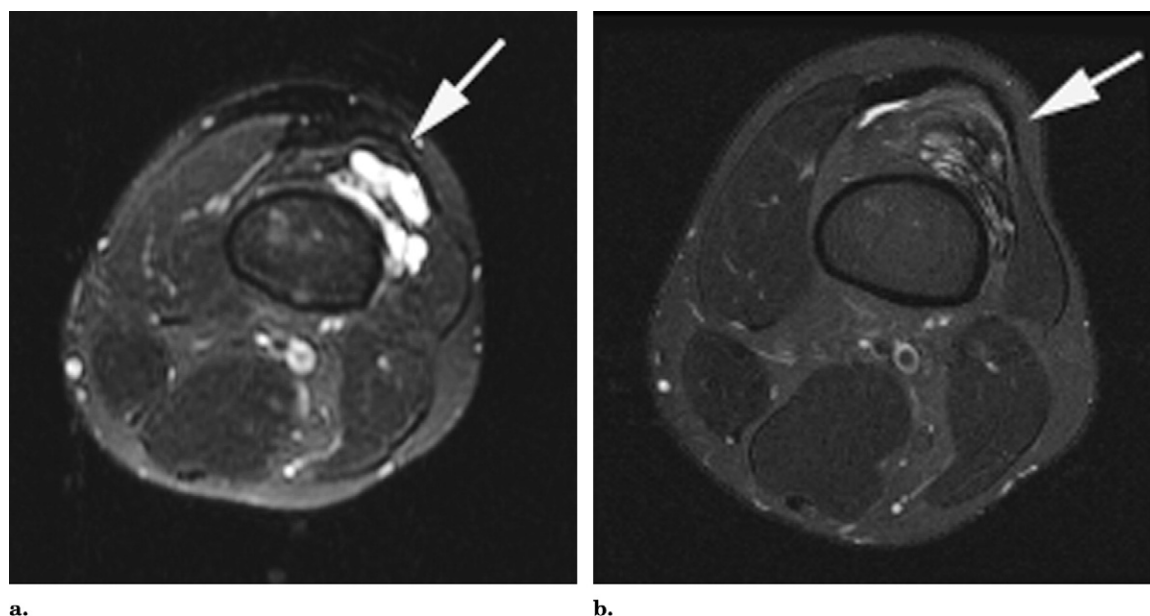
Images in a 35-year-old man with a painful infiltrative thigh malformation who underwent two treatment sessions with foam STS. This case demonstrates that a good radiologic outcome does not always translate to a good clinical outcome. (a, b) Fat-suppressed T2-weighted MR images obtained before (a) and after (b) treatment show almost complete resolution of the malformation (arrow). Despite a good radiologic outcome, the patient remains symptomatic.
